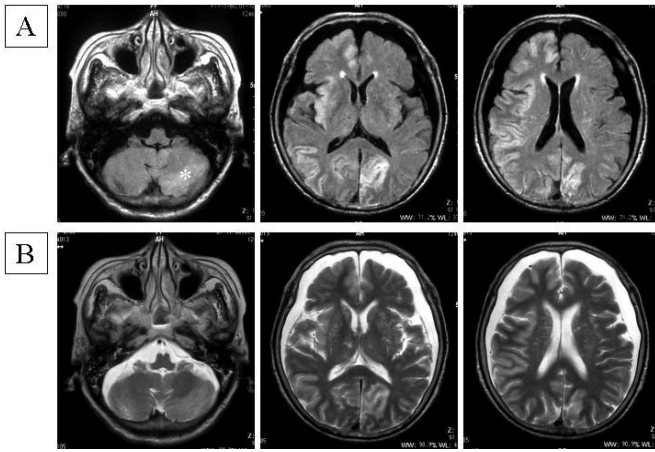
The magnetic resonance image on the 5th day after hypoglycemic coma. The axial fluid-attenuated inversion recovery (FLAIR) (A) and T₂-weighted (B) images during focal status epilepticus demonstrated increased signal intensity in the right cerebral cortex including insular regions and the left occipital cortex. Increased signal intensity was also seen in the left cerebellar cortex (*).
